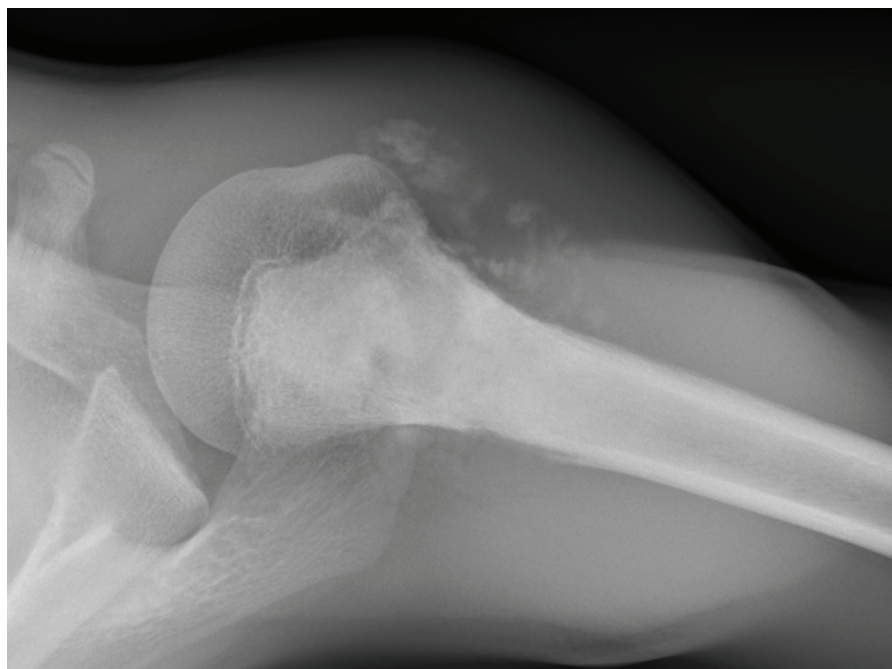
Codman triangle in osteosarcoma of the proximal humerus in X-ray a.p. projection.*
